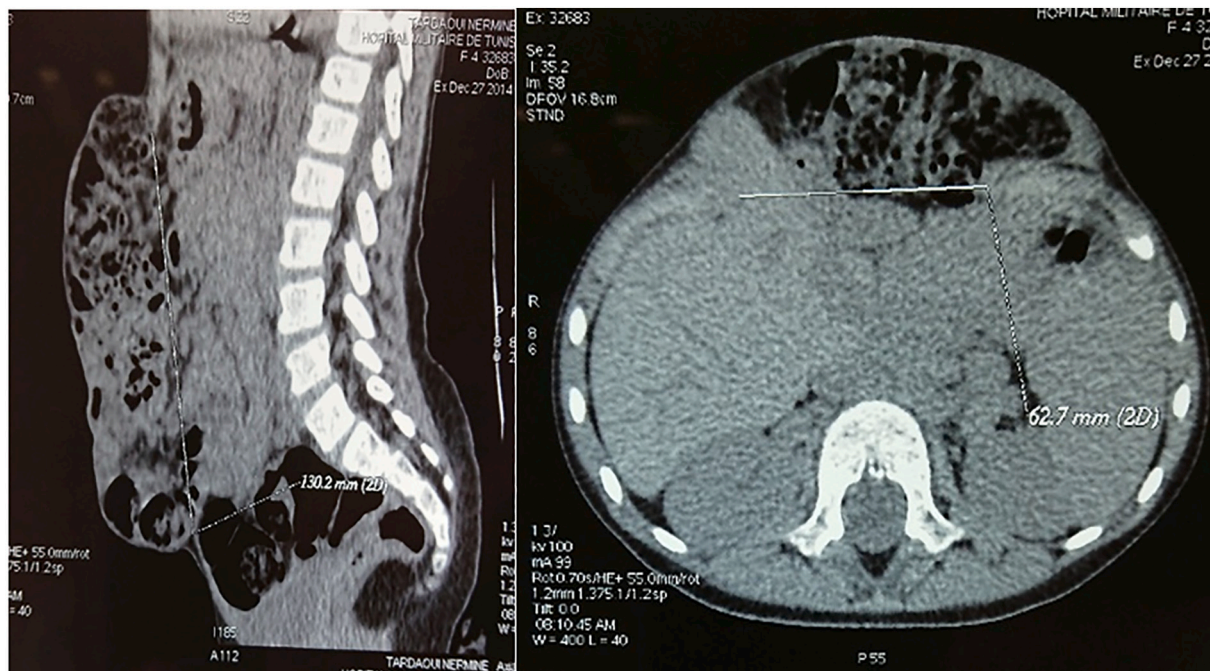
CT scan: defect of abdominal muscles extending from the metasternum to the hypogastric region realizing a broad collar of 150 mm.
